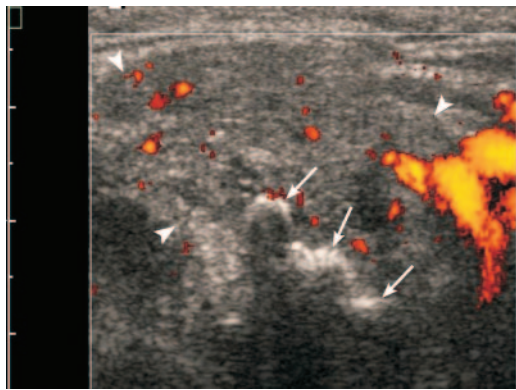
Power Doppler US image shows chronic inflammation of the left submandibular gland (arrowheads). The gland is inhomogeneous with decreased parenchymal echogenicity but without increased blood flow. Arrows = stones.
